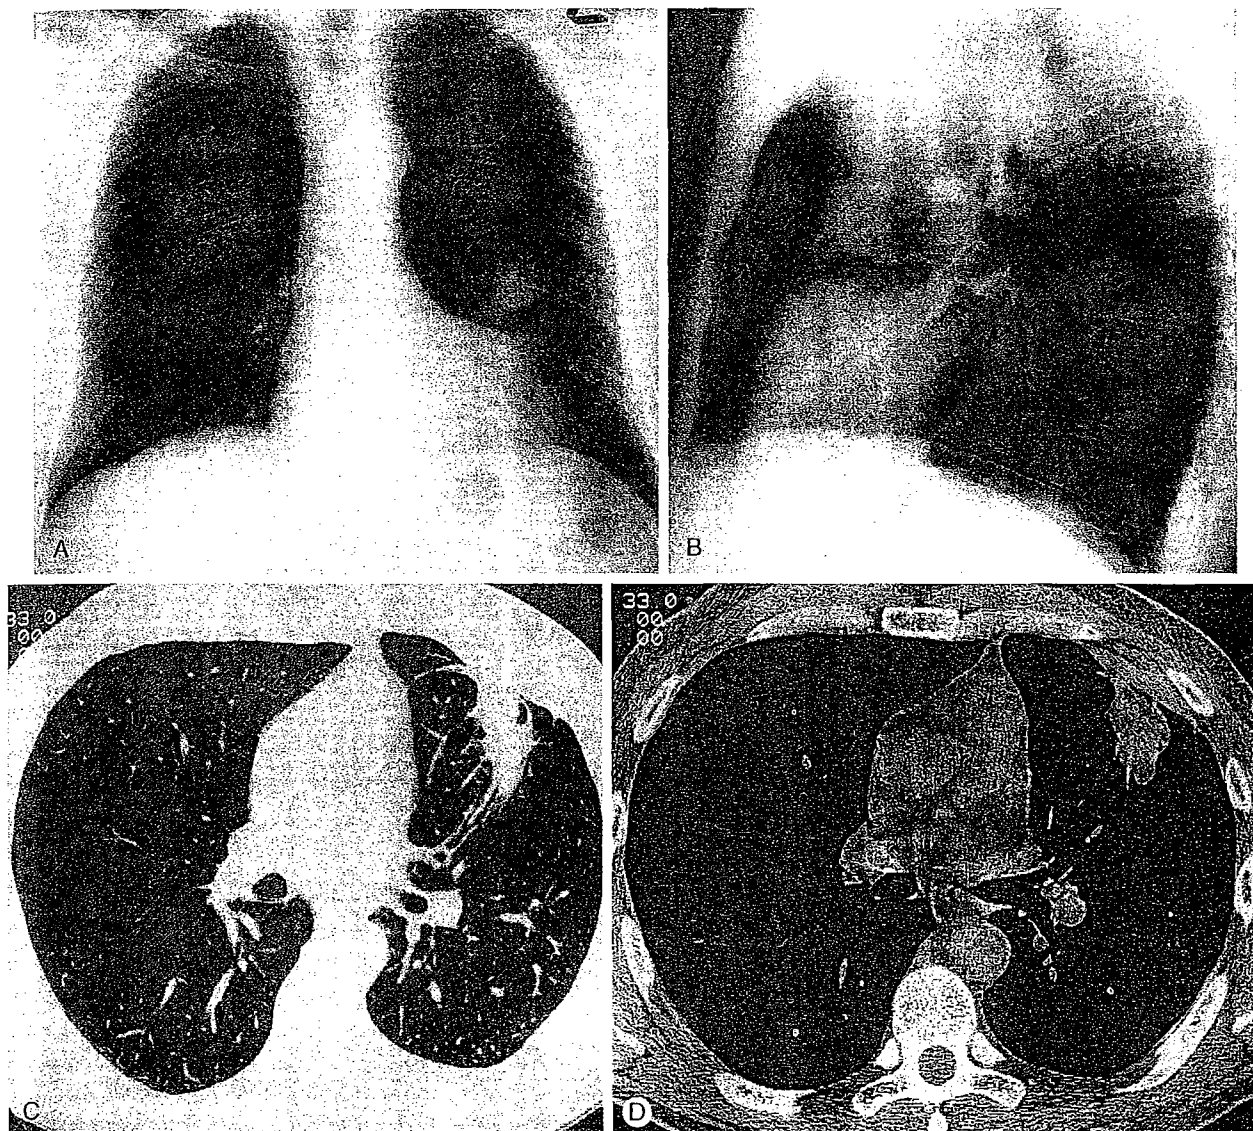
Round Atelectasis. A 54-year-old man with a long-standing history of exposure to asbestos was referred for evaluation of a suspected left lung mass. Posteroanterior (A) and lateral (B) chest radiographs demonstrate evidence of left pleural thickening and a 3-cm mass in the left lung. The margins of the mass are poorly defined, indicating that it is pleural based. An HRCT scan (C) demonstrates an oval soft tissue mass in the lingula associated with loss of volume and anterior displacement of the major fissure. Vessels and bronchi can be seen curving into and sweeping around the area of atelectasis. Soft tissue windows (D) demonstrate that the area of atelectasis abuts a focal area of pleural thickening. The size of the mass was stable over a 3-year follow-up period.
